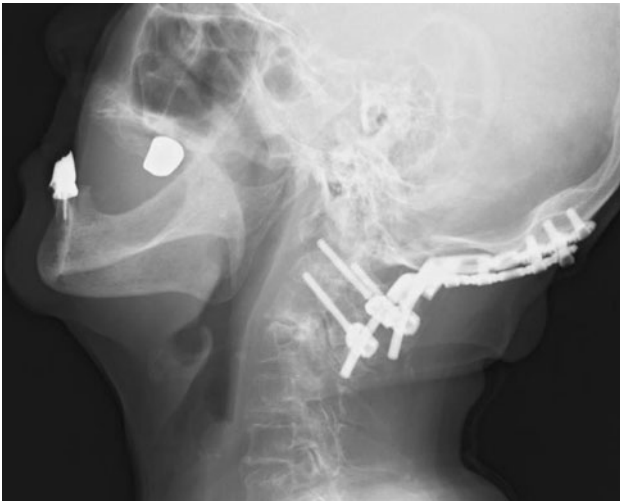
Patient 1: lateral view of the radiograph of the neck after posterior occipitocervical (O-C2) fusion taken two and a half months before the episode of cardiopulmonary arrest (CPA). Extension and flexion of the neck is limited
